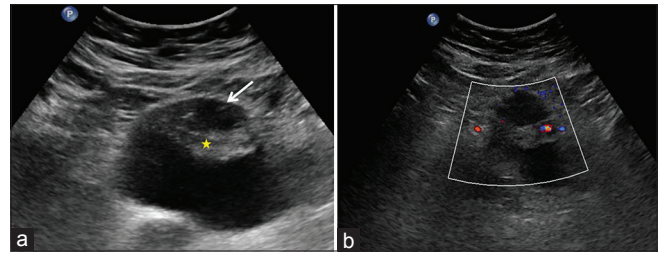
Ultrasound pelvis shows a heterogeneous lesion with a central oval-shaped cystic component (thick white arrow) within focally thickened apico-anterior bladder wall (yellow star) (a). Color Doppler reveals color flow within the mass and no flow in the central cystic component (b)
